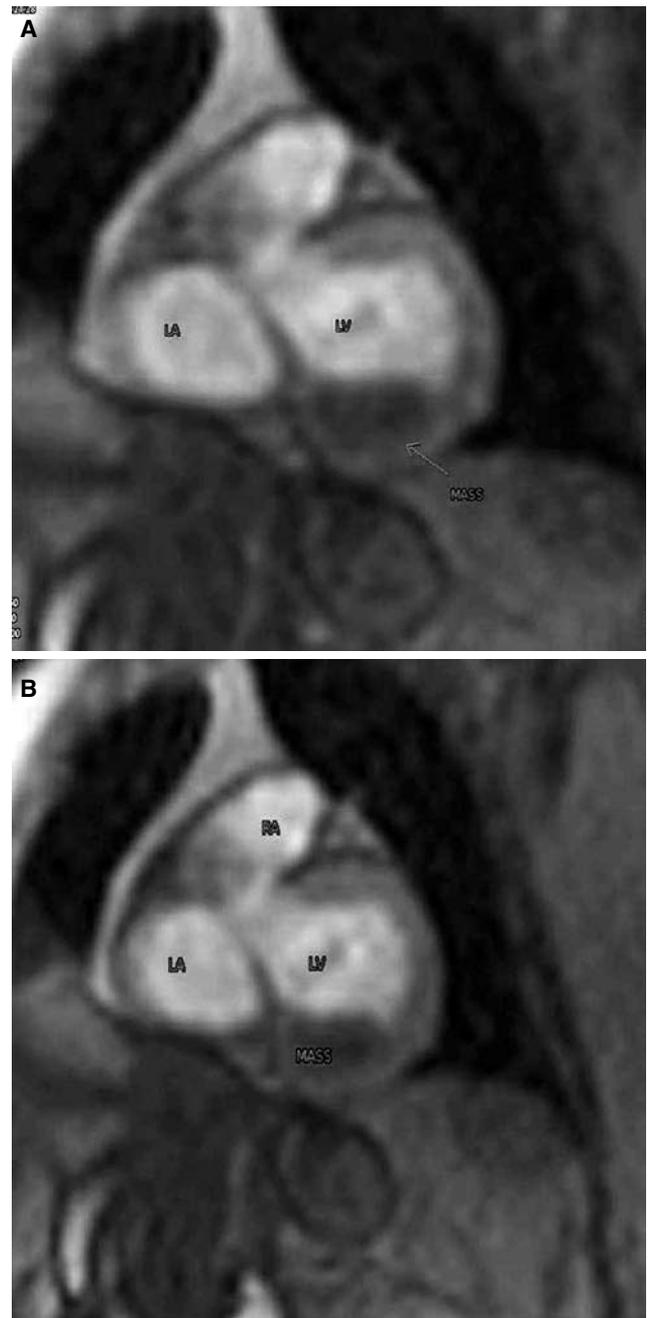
(A) Unenhanced MRI view showing involvement of the posterior mitral annulus and adjacent myocardium. (B) Contrast-enhanced MRI showing no perfusion of the mass.
